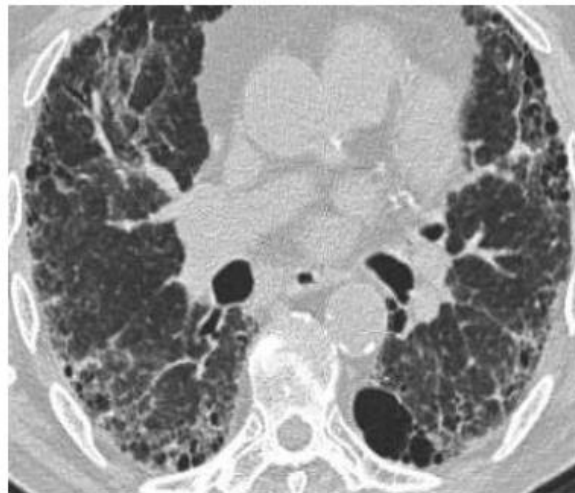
CT of pulmonary fibrotic lungs.
